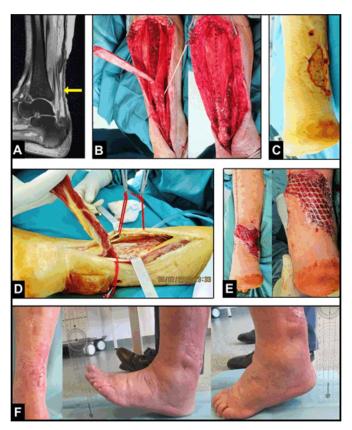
(A) Magnetic resonance image demonstrating chronically destroyed Achilles tendon (arrow), (B) Clinical photographs showing open augmented repair of Achilles tendon intraoperatively, (C) Clinical photograph showing large necrotizing soft tissue defect postoperatively, (D) Clinical photograph demonstrating harvesting of distally pedicled peroneus brevis muscle flap intraoperatively, (E) Clinical photographs showing transposition of peroneus brevis muscle before and after skin grafting intraoperatively, and (F) Clinical photographs postoperatively showing uncomplicated wound healing with preserving of eversion and plantar flexion of foot.
